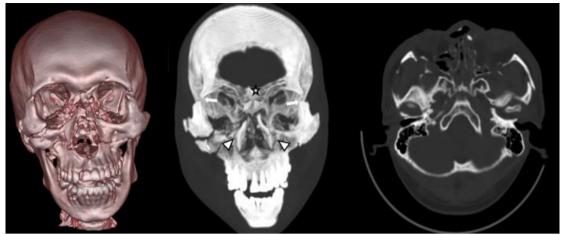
A 36 years old male hit by a falling tree on the face. On Head CT exam, there are fractures on the bilateral orbital lateral-inferior-medial wall, nasofrontal junction (star), zygomafrontalis suture (thick arrow), processus pterygoid medial and lateral which gives the impression of a floating face on 3D images, which is a characteristic for Le Fort fracture type III. On this patient, we can also see fracture of the right zygoma arch and also fracture that causes the separation of the right zygoma bone from the calvaria which is a right side zygomaticomaxillary complex fracture.
